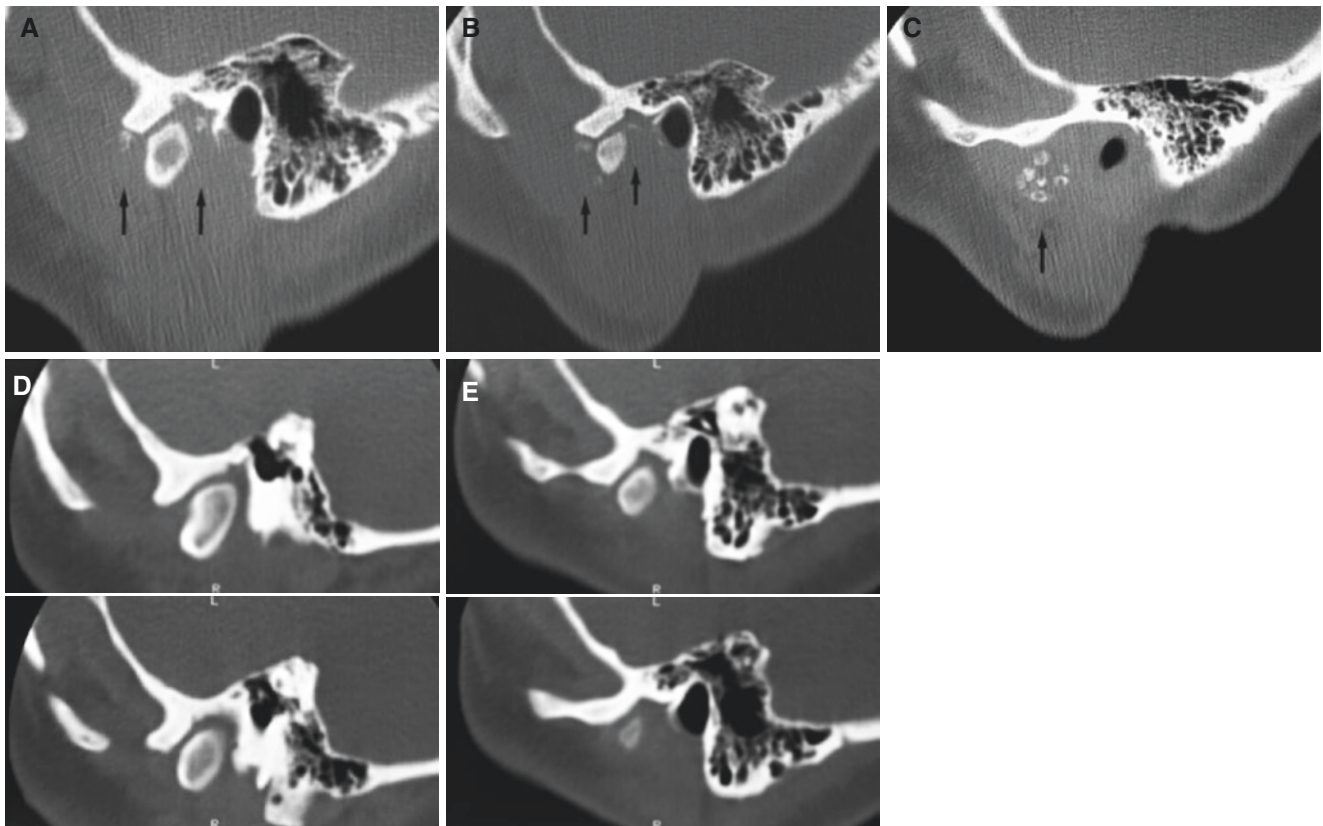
Synovial chondromatosis. (A, B, C) Oblique sagittal CT images show multiple soft-tissue calcifications (*arrows*) anterior, posterior, and lateral to the condyle. (D, E) Four oblique sagittal CT images
